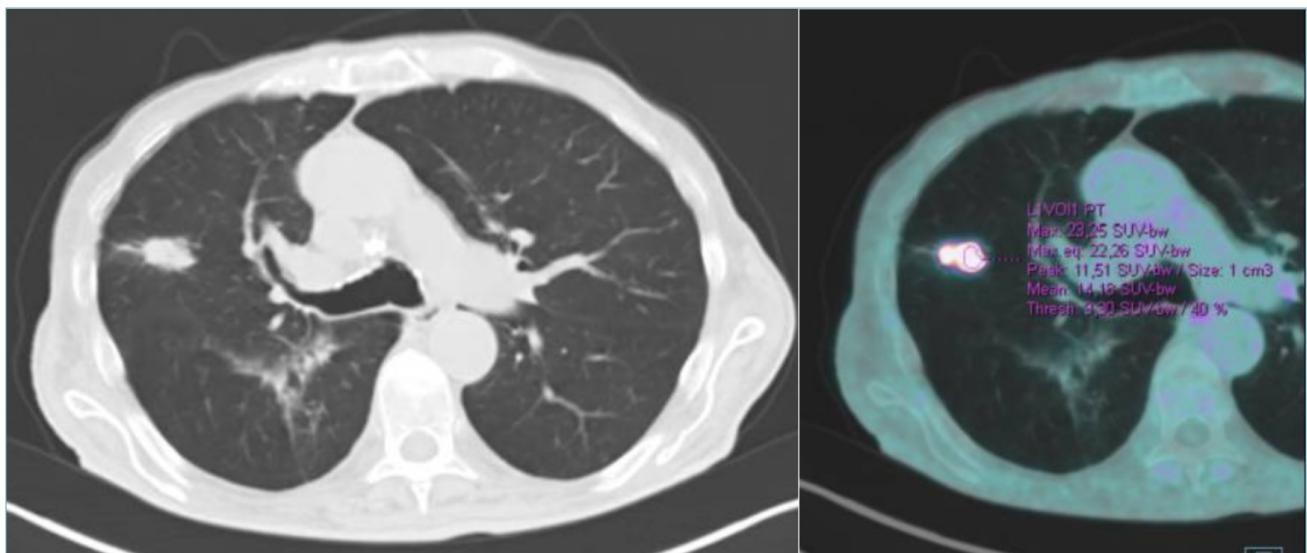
Pre-operative CT scan and 18FDG-PET CT, showing right upper lobe lesion
